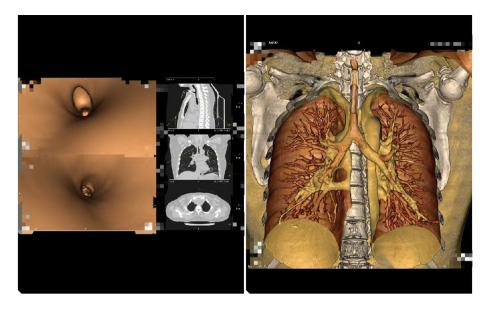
Three-dimensional airway reconstruction computed tomography (CT) image from September 2023. (A) The dumbbell-shaped trachea was observed below the vocal cords and above the apex of the heart. (B) Airway stenosis was observed where the tracheal T-tube was placed.
